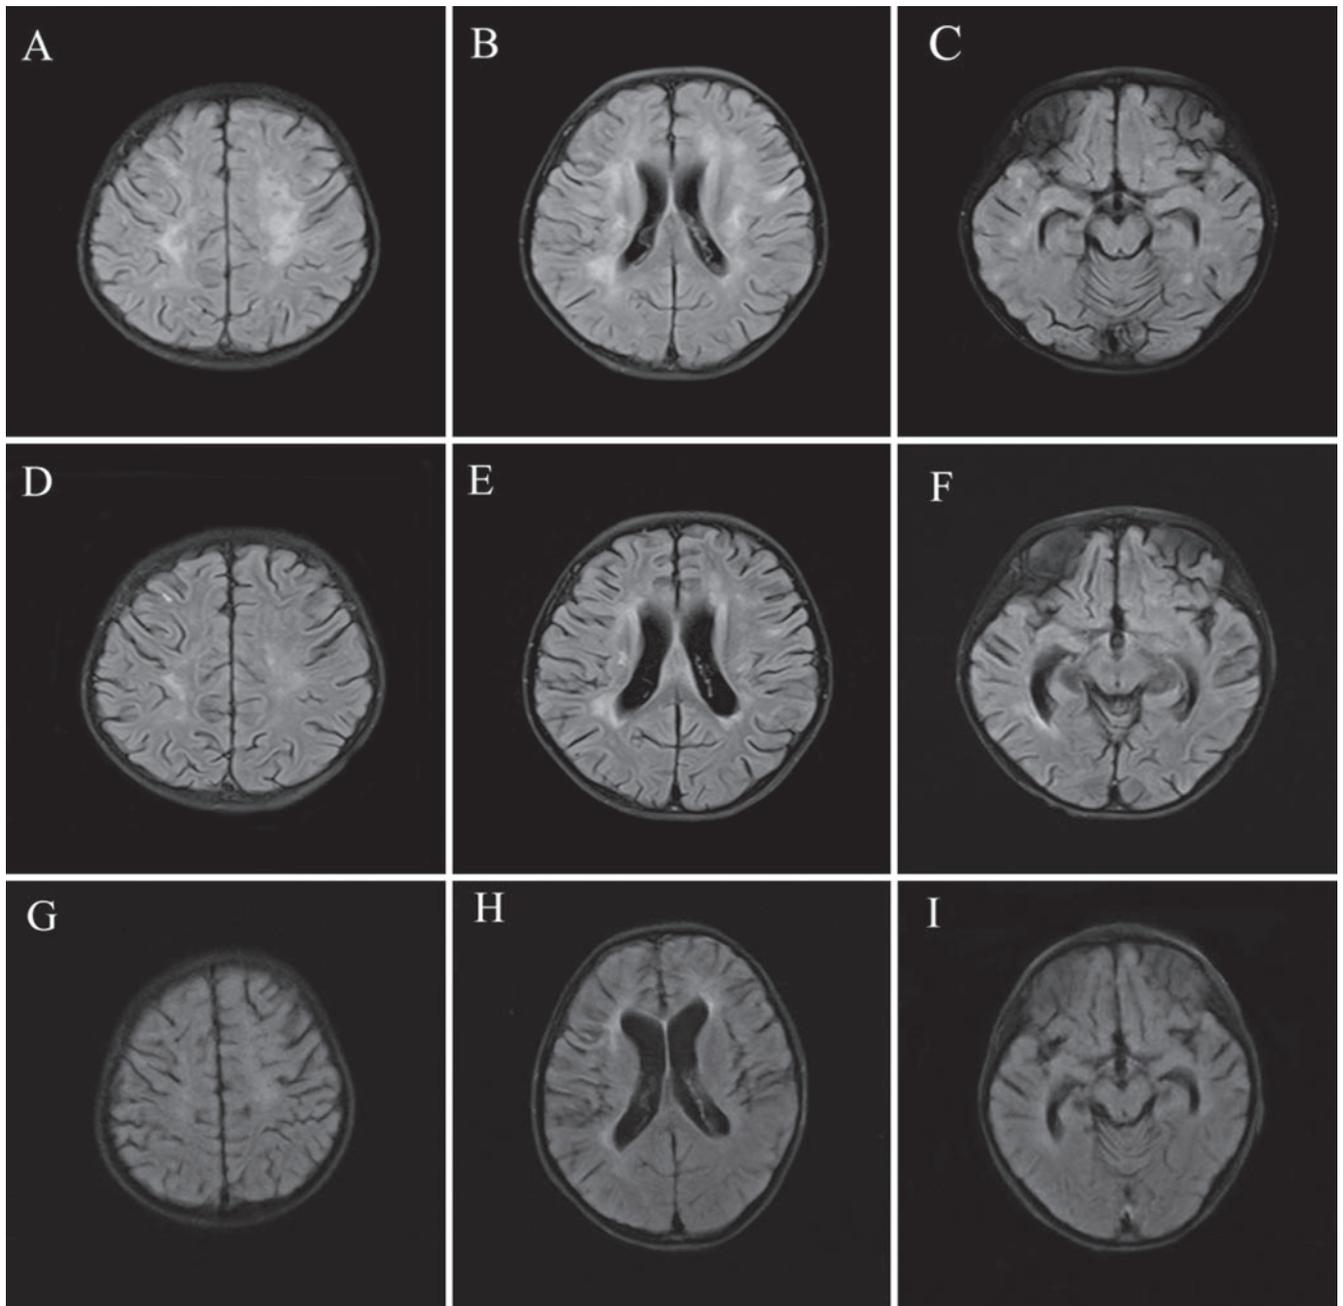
Magnetic resonance imaging (MRI) results in the brain. Before the immunotherapy, bilateral widespread changes in fluid-attenuated inversion recovery (FLAIR) sequences in the cerebrum, especially white matter in the top of bilateral cerebral ventricles and centrum semiovale, the boundary of the lesions were obscure (A, B and C). After 9 days of immunotherapy, the foci of abnormal signal in FLAIR sequences were remarkably reduced in number and size (D, E and F). Six months later, MRI showed mild cerebral atrophy, expanded ventricles and slight demyelination in the horns of lateral ventricles and centrum semiovale (G, H and I).
